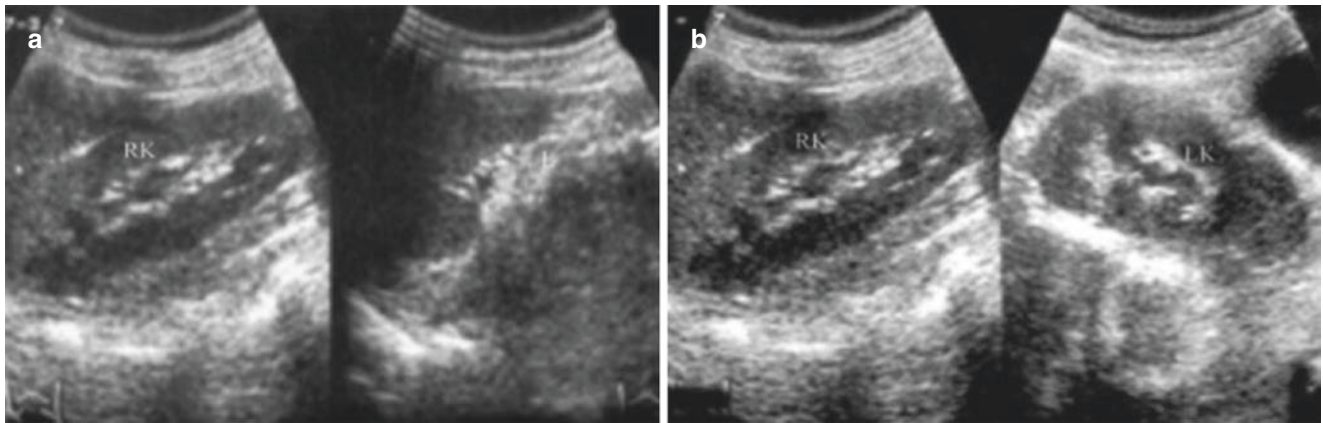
The absence of kidney (a) and ectopic kidney (b) A 28-year-old patient represented with primary amenorrhea. Ultrasonography shows no uterus and ovary, with absent left kidney and normal right
